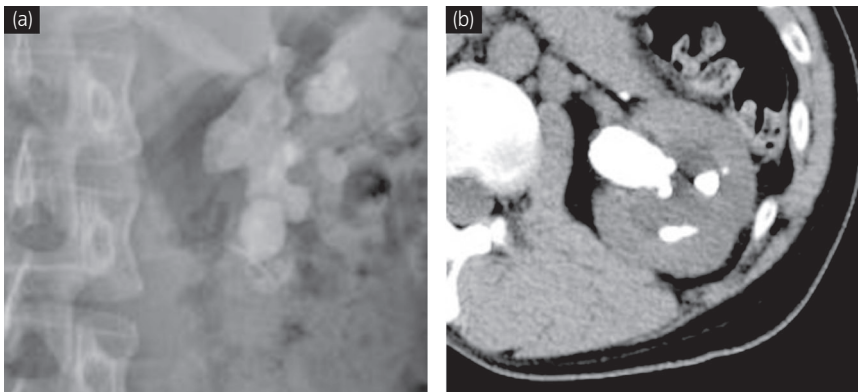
Preoperative kidney-ureter-bladder radiography (a) and computed tomography (b) demonstrated presence of left staghorn calculus.
